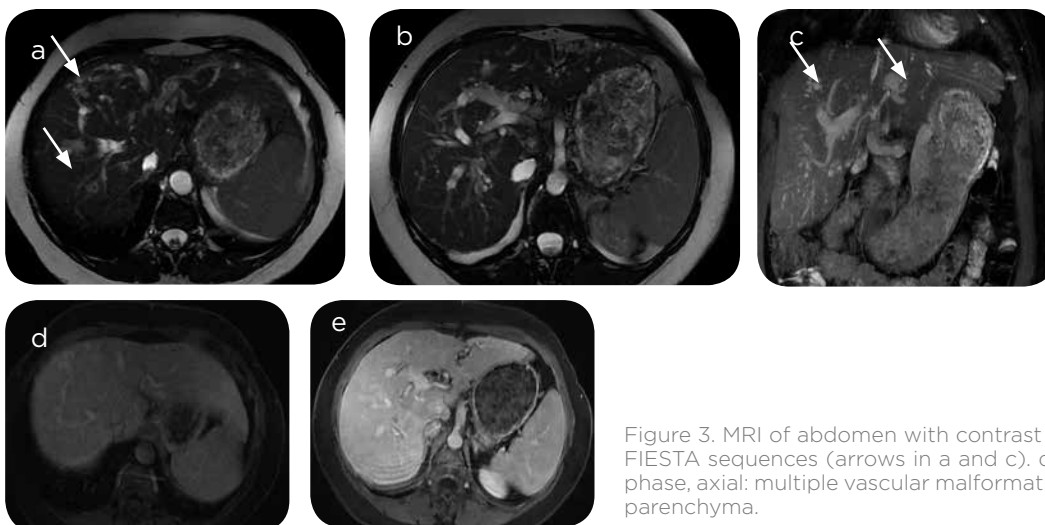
MRI of abdomen with contrast medium. a-c) axial and coronal FIESTA sequences (arrows in a and c). d-e) T1 + Gd dynamic in arterial phase, axial: multiple vascular malformations are observed in the hepatic parenchyma.
